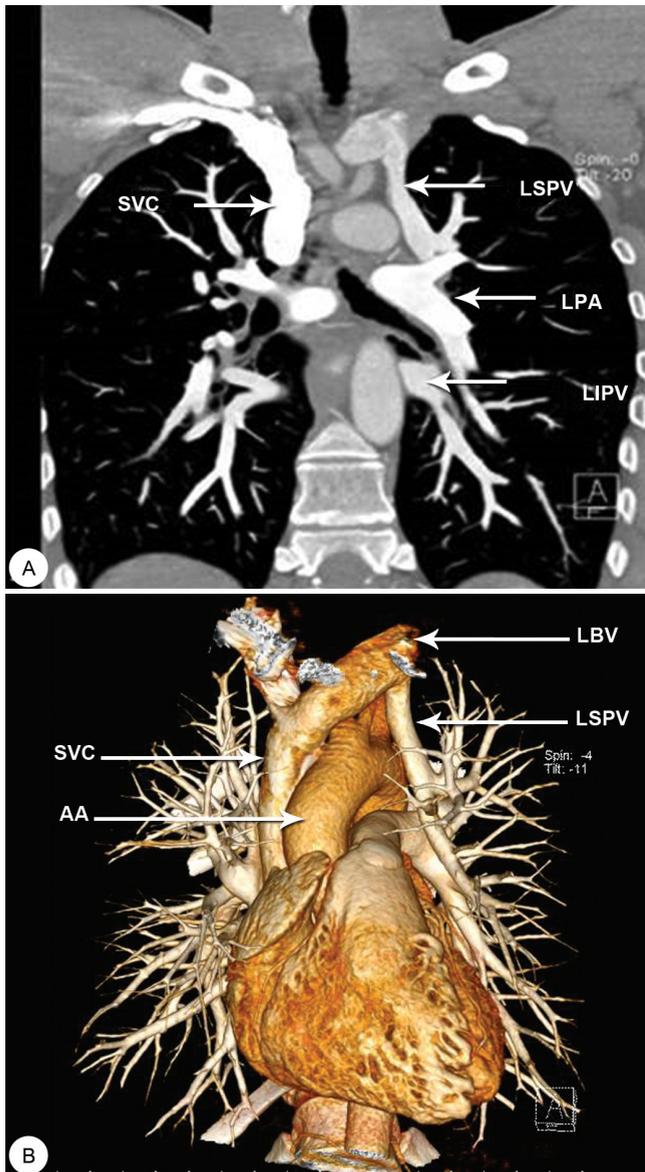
The images present the cardiac computed tomography angiography performed on the patient.
